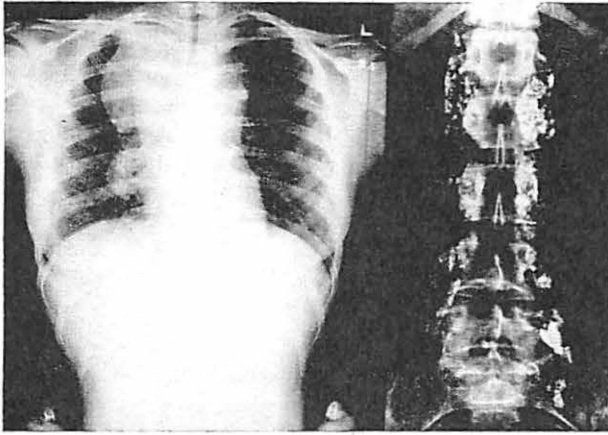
Type 2 Female (26 yrs) from whom right supraclavicular lymph node biopsy showed Hodgkin's Disease with M. C. Chest radiograph shows gross mediastinal and contiguous adenopathy. Note numerous small opacified glands with irregularity of contour and parenchymal defects due to H. D. with M. C. at laparotomy.
